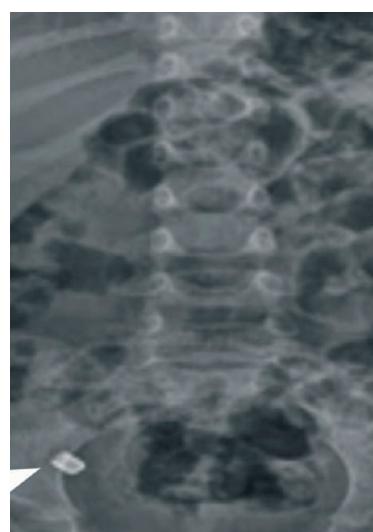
Direct abdominal radiography. Foreign body (arrow) in the right inguinal region
